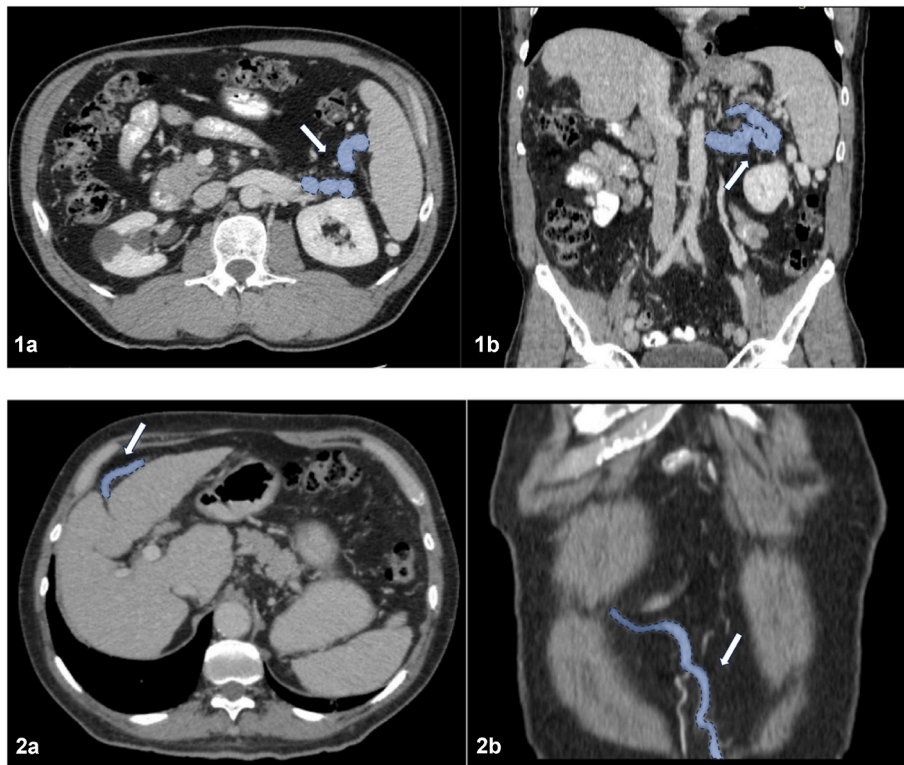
Identification and characterization of the spontaneous portosystemic shunts (SPSS) on the pre-operative contrast-enhanced CT scans. CT appearance of a spleno-renal shunt in the axial (1a) and coronal (1b) planes and of an umbilical-epigastric shunt in the axial (2a) and coronal (2b) planes.
